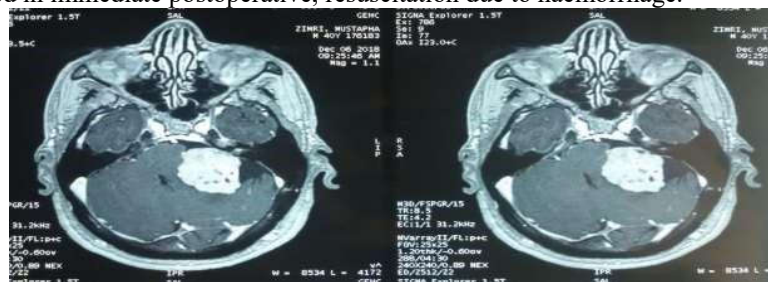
MRI image in axial section T2 sequence showing a NA of the cerebellar Ponto angle.
